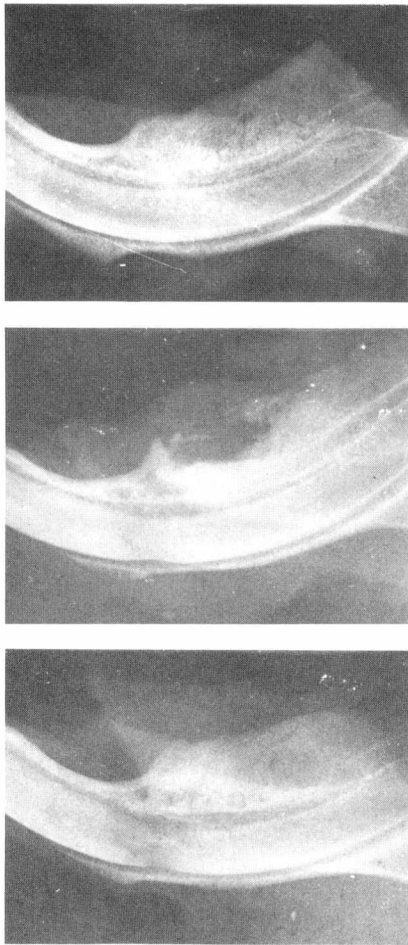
Radiographic appearance 30 days post-extraction. Upper: control, medium: irradiated; lower: irradiated and injected with EHDP.
